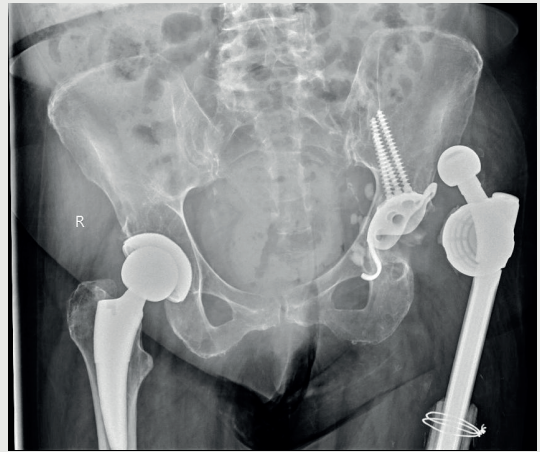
Preoperative X-ray of the left pelvis (a.p.), dorsal dislocation of the dual mobility shell out of the acetabular reinforcement ring
